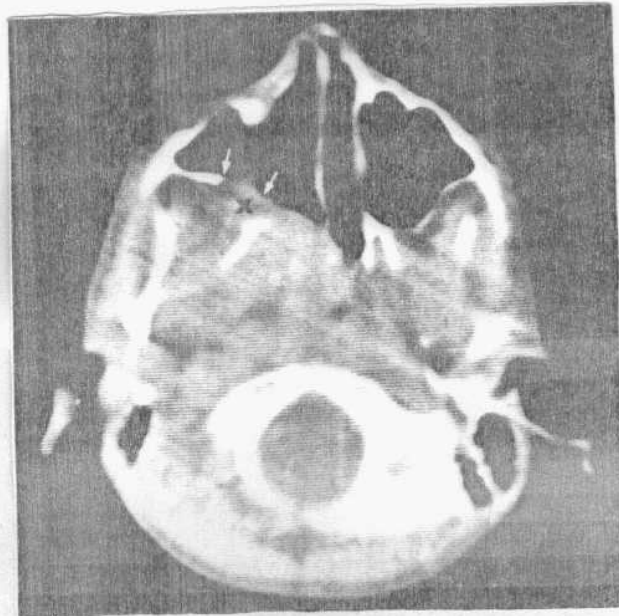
Axial CT scan reveals anterior displacement and thinning of right posterior antral wall (arrow) with indenting of pterygopalatine space (X) and destruction of medial pterygoid process. There is a large nasopharyngeal mass. Juvenile angiofibroma.
